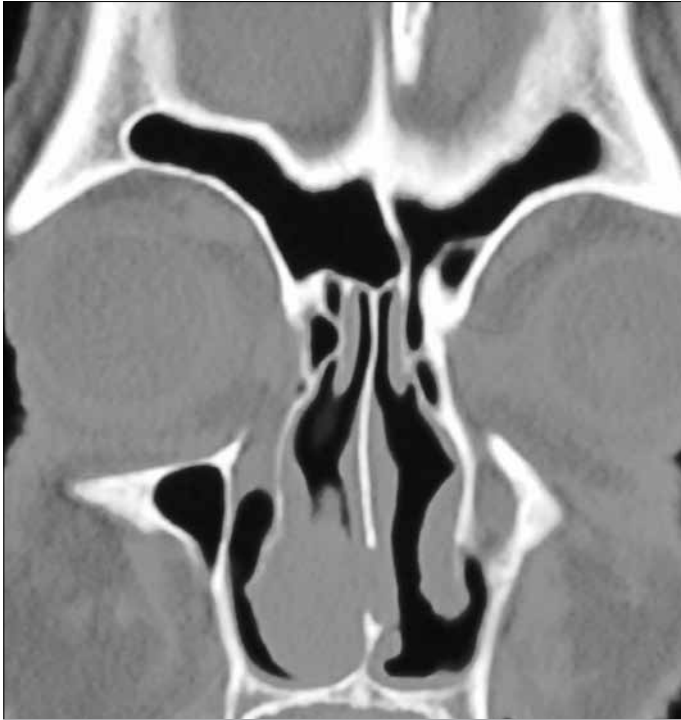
Paranasal sinuses are normal, with no signs of infection or polyposis in the paranasal CT
